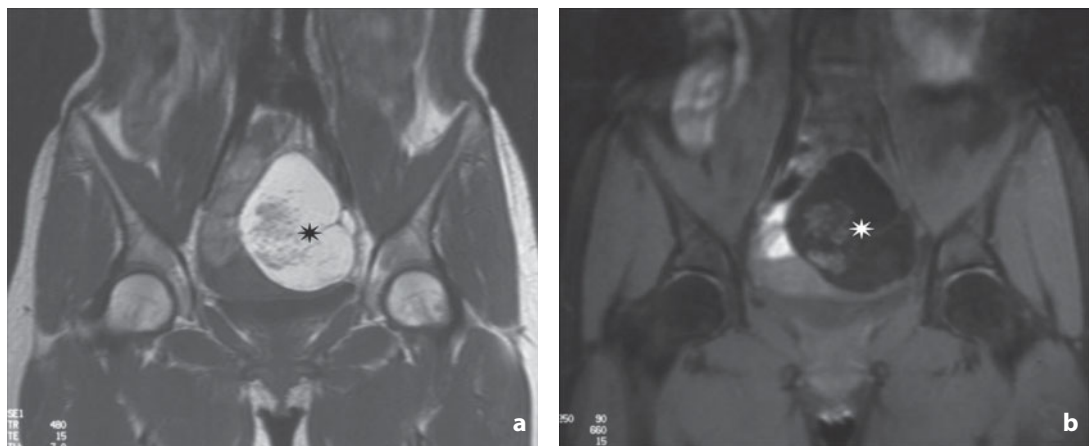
Magnetic resonance. Cystic teratoma. In the left parauterine space a mass (*asterisk*) can be visualized with prevalently hyperintense signal in the T1-weighted sequence (a). The loss of signal after fat signal saturation (b) confirms the adipose structure of the lesion
